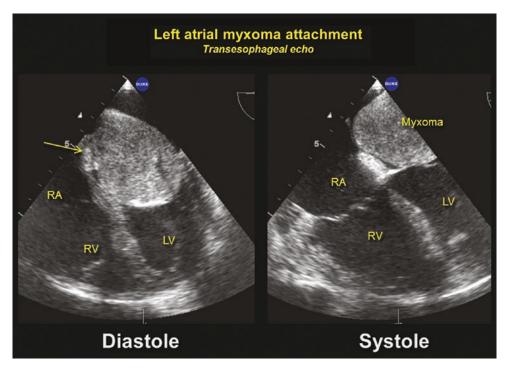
Transesophageal echo showing the point of attachment of a myxoma on the atrial septum in the fossa ovalis. It is important to find the point of attachment to aid in directing the approach for surgical removal of the mass
